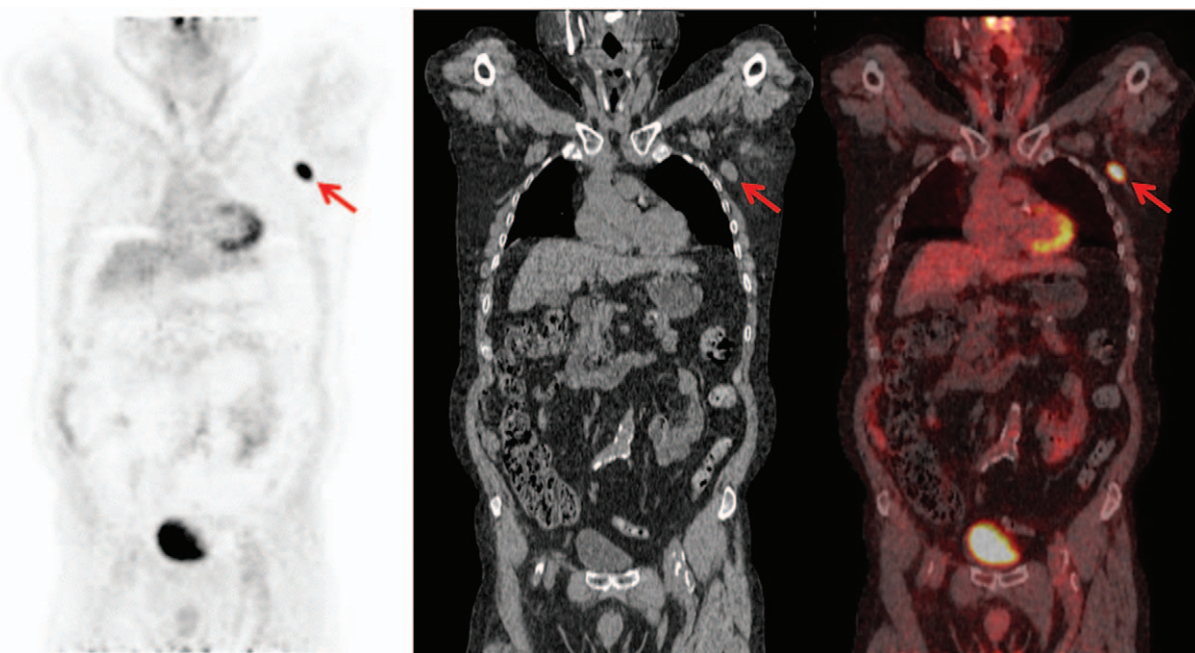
Coronal positron emission tomography image (left), computed tomography image (middle), and fused positron emission tomography/computed tomography image (right) in a patient with known anti-neutrophil cytoplasmic antibody-associated vasculitis referred owing to a suspicion of cancer. There is focally increased ^{18}F -fluoro-deoxy-glucose uptake in an enlarged left axillary lymph node (red arrows). Subsequent biopsy confirmed a diagnosis of diffuse large B-cell lymphoma.
